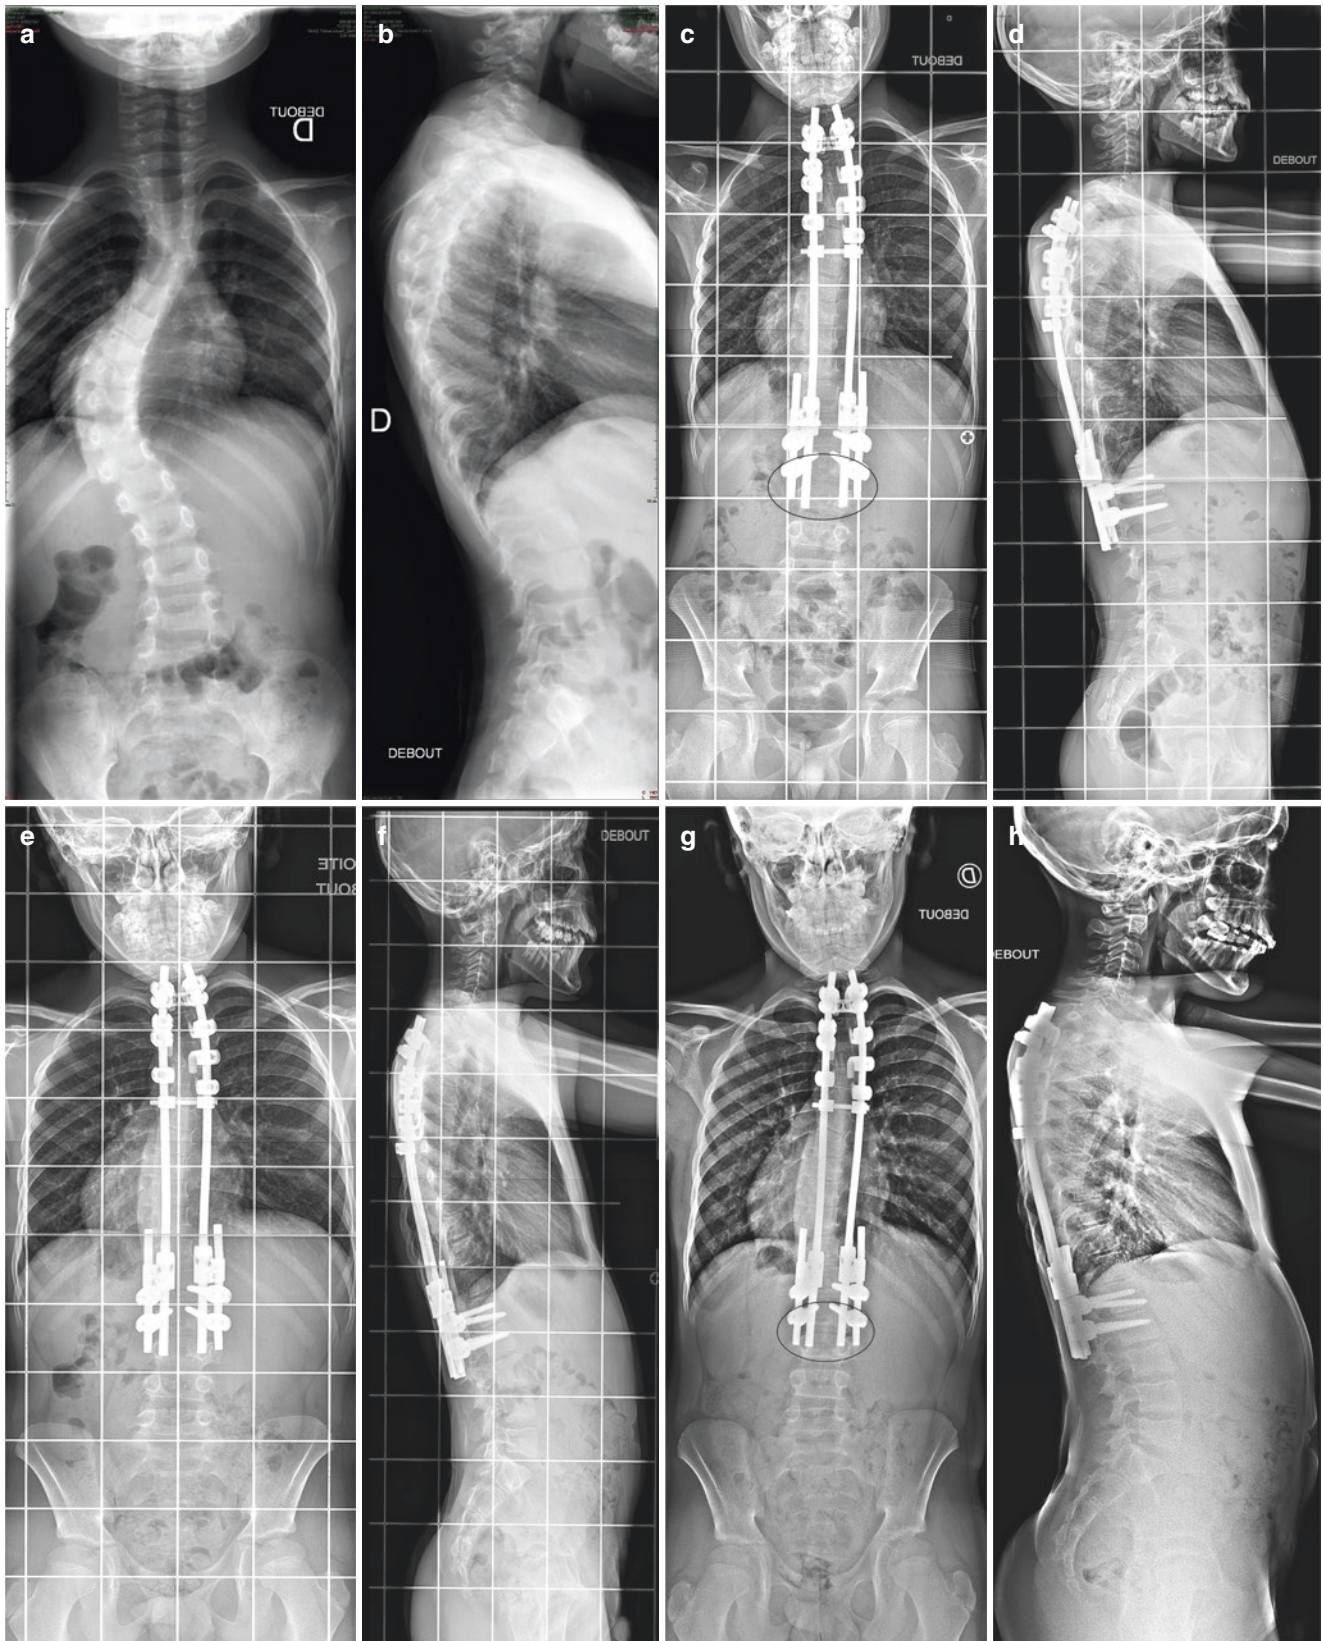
Case of an idiopathic EOS 7-year-old patient. Preoperative radiographs (a, b), postoperative (c, d), 2 years postoperative (e, f), 3 years postoperative (g, h), preoperative picture of the patient (i, j), and 3 years postoperative (k, l)
